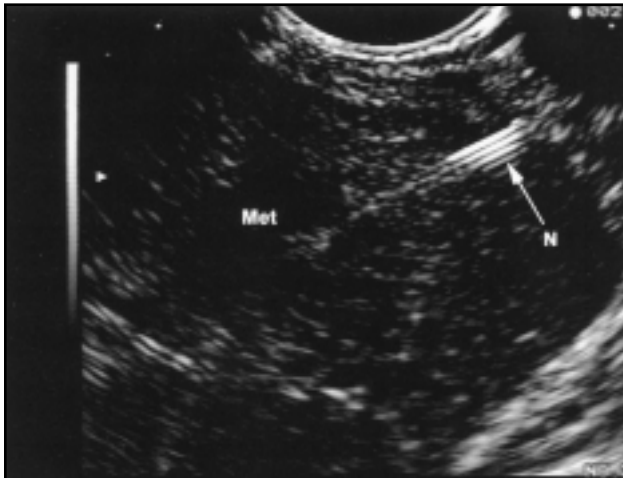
Linear array EUS view showing FNA of an irregularly shaped hypoechoic lesion (Met) in the periphery of the liver. This lesion was not detected by CT scan and ultimately was shown to be a metastasis from a pancreatic adenocarcinoma. N = needle.
